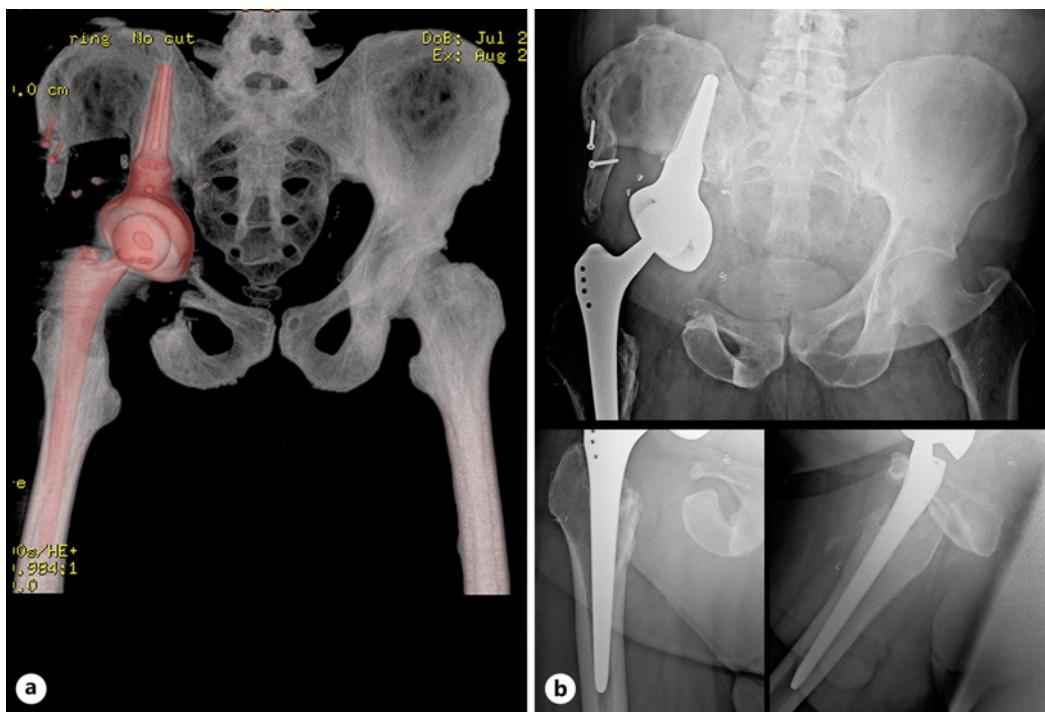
3D-CT – reconstruction image (a), August 2011 10 days after resection of the metastasis and reconstruction with LUMIC® endoprosthesis. X-ray documentation (b) 12 years later June 2023.
